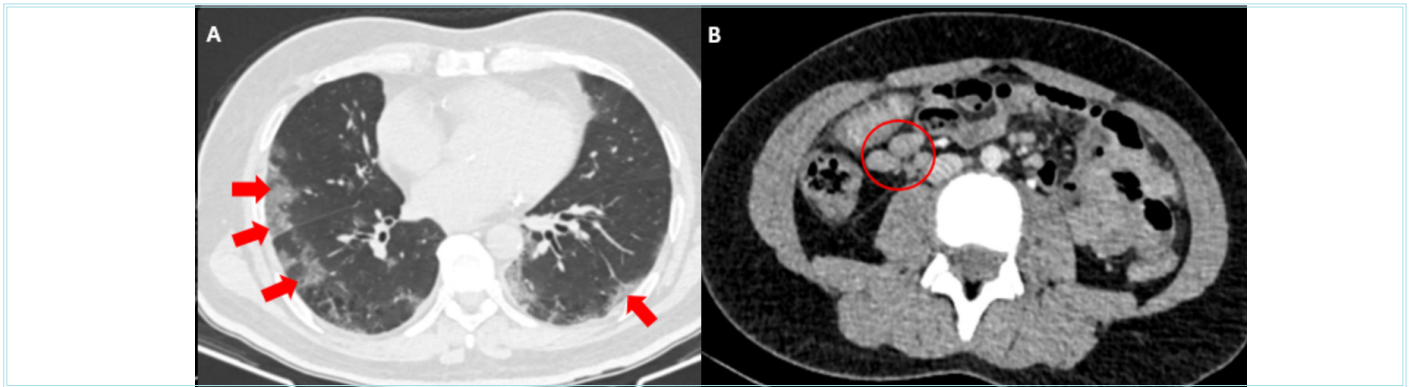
A) Non-contrast thorax CT axial slices show diffuse peripheral ground-glass opacities in a 35-year-old male patient with a diagnosis of COVID-19 (arrows). B) Contrast-enhanced abdominal CT axial sections show mesenteric lymphadenopathies with a short axis greater than 1 cm in the parahcecal area in the right lower quadrant of the abdomen in the same patient with COVID-19 (circle). When evaluated together with clinical and laboratory data, it was confirmed to be compatible with mesenteric lymphadenitis
